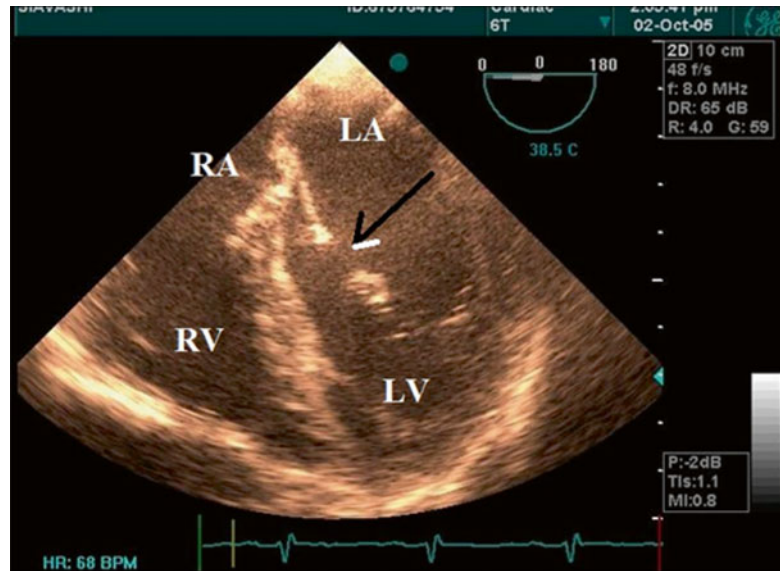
Isolated mitral valve cleft as 2D defect in anterior mitral leaflet in transesophageal echocardiography
